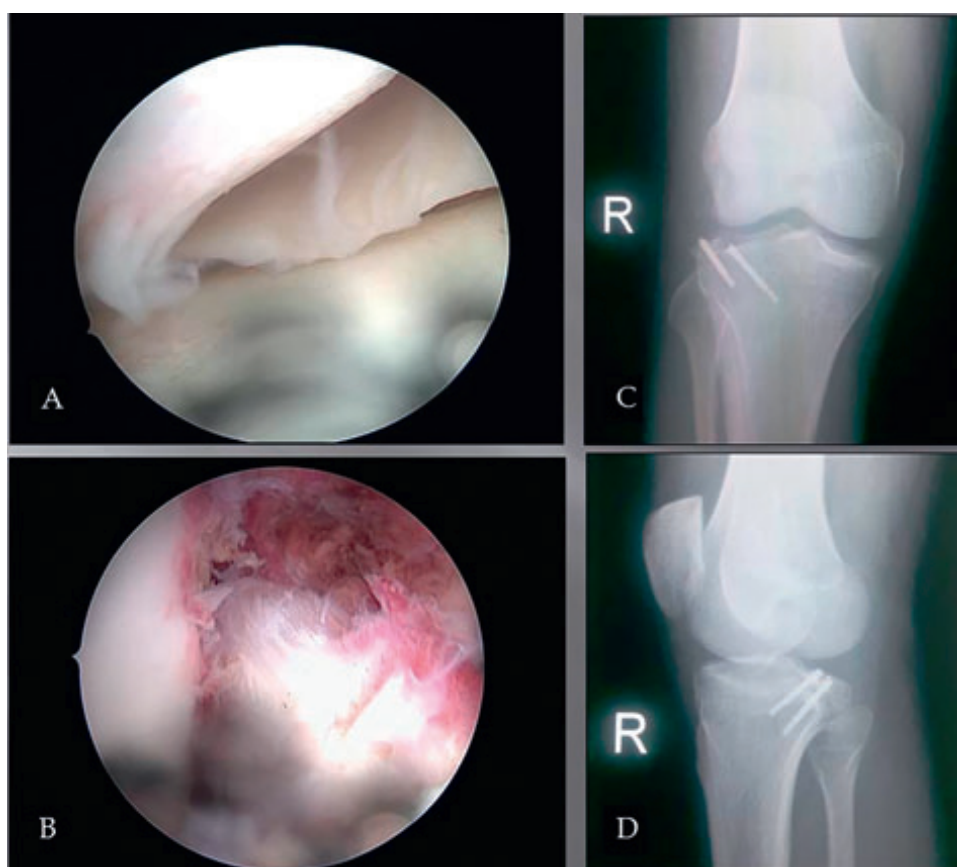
(A) Intra-operative image showing the retrieval of loose fragments (B) Intra-operative image showing loose fragments (C) Immediate post-operative radiograph showing the fracture fixation (anteroposterior view) (D) Immediate post-operative radiograph showing the fracture fixation (lateral view).
